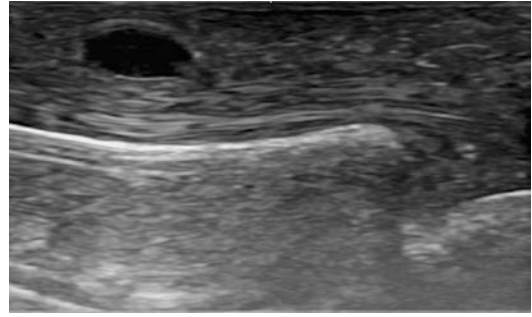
A2 RB pulley ganglion in a longitudinal ultrasound plane
